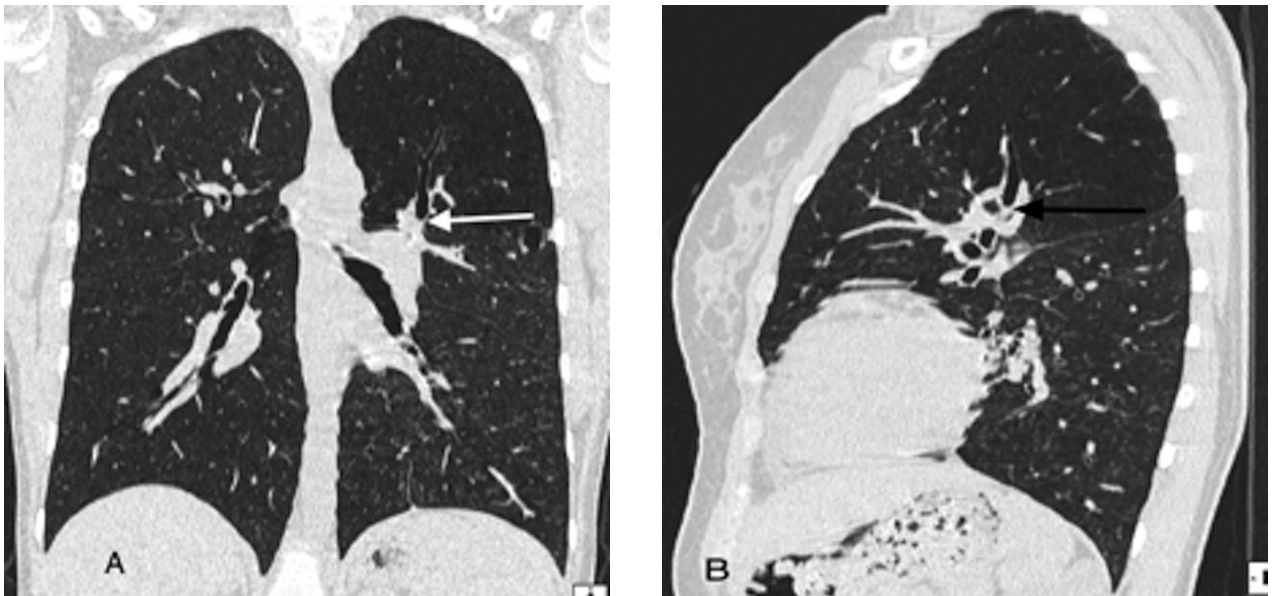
Stenosis of the afferent bronchus for the dorsal segment of the left upper lobe: (A) CT coronal projection (B) CT sagittal projection
